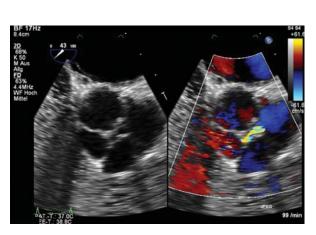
Transesophageal echocardiogram (2-dimensional short-axis view) shows the quadricuspid aortic valve. At right, color flow indicates aortic regurgitation.
